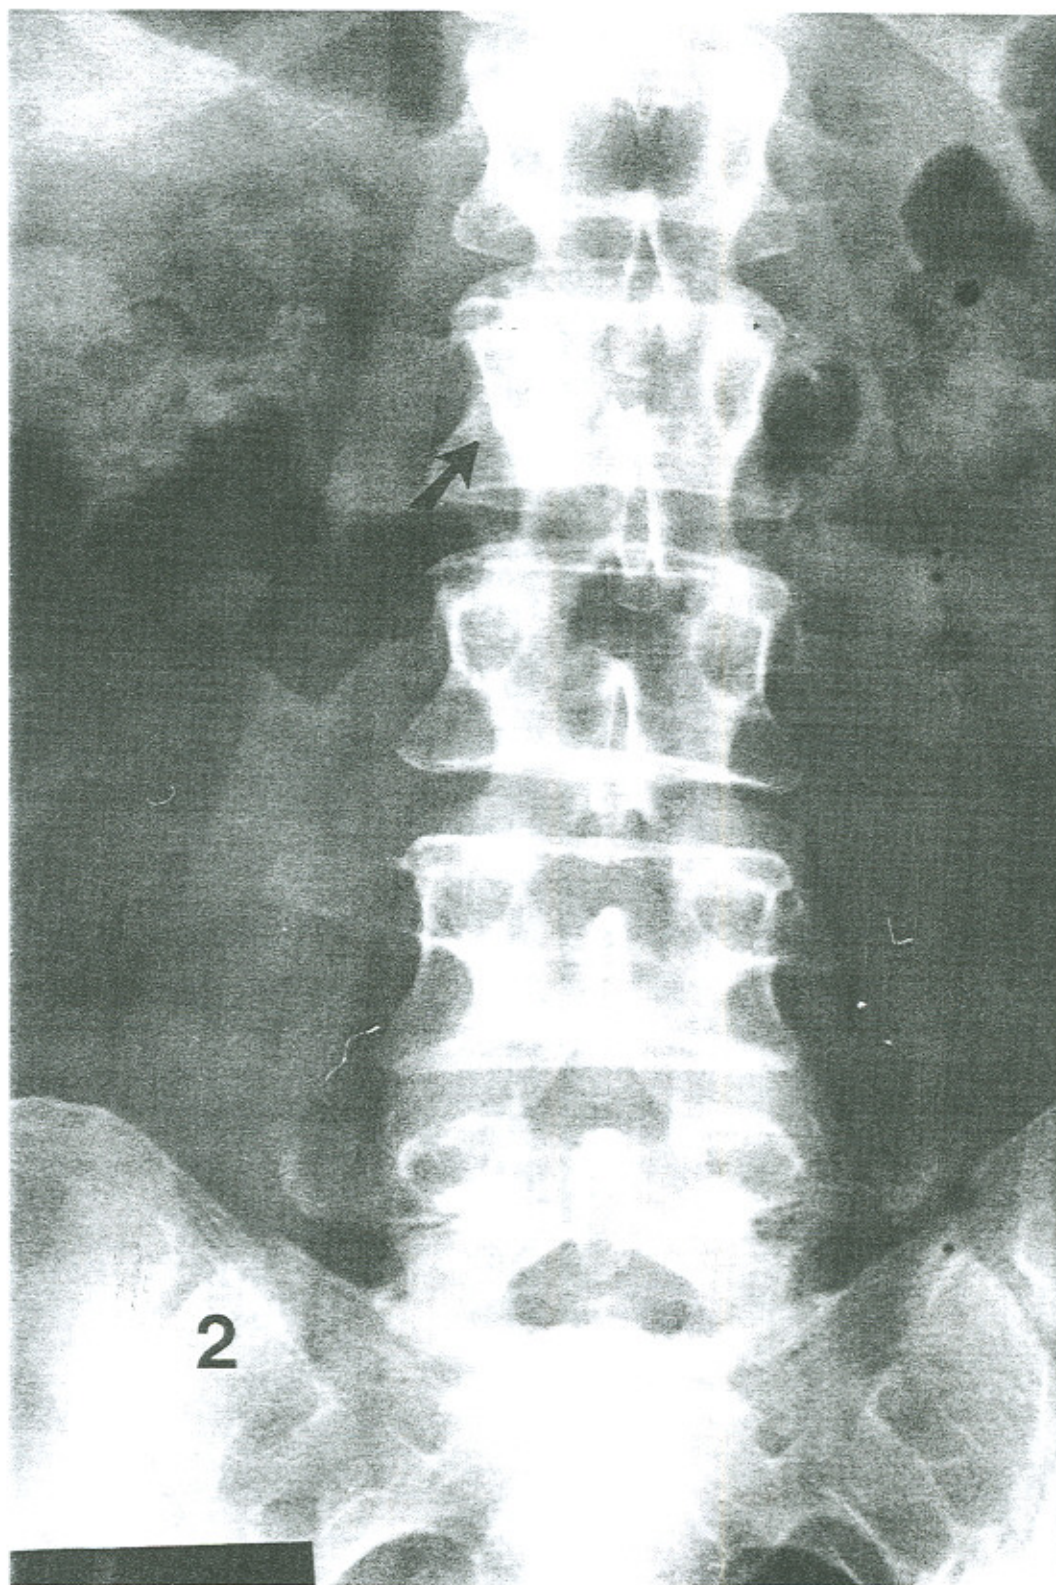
Increased density of the right pedicle (arrow) is visualized on the AP radiograph.
